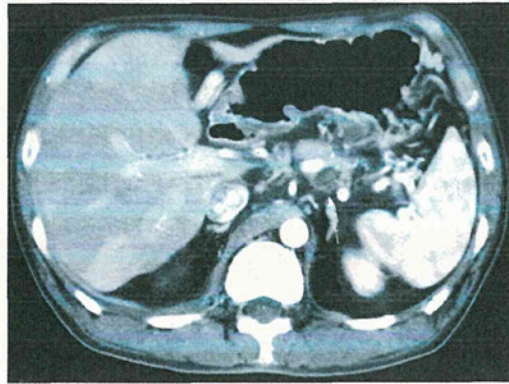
Abdominal computed tomographic findings. A severely atrophied pancreas with a calcified body was noted. The pseudocyst (arrow) ranged from the back of the pancreas to the left mediastinum and was adjacent to the splenic artery.
